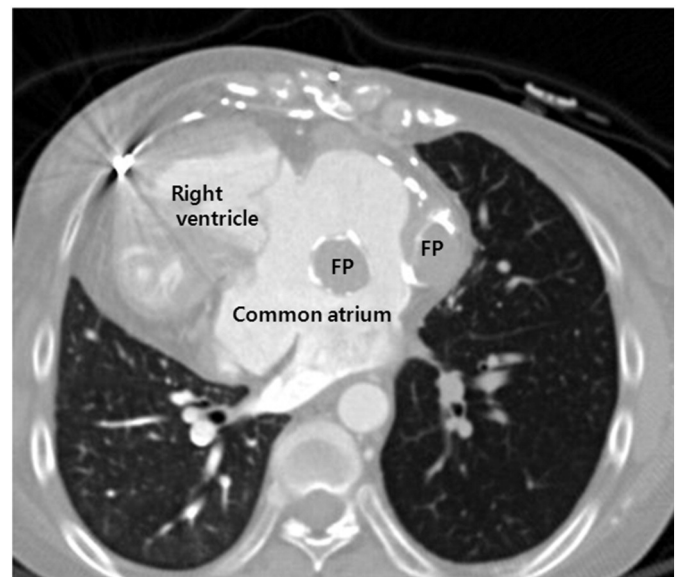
Chest CT scan of a patient with highly recurrent IART. This patient had right ventricle type single ventricle with mitral atresia, left isomerism, dextrocardia and dual Fontan pathway after LT Fontan conversion. In this patient, IART was highly recurrent despite Fontan conversion, right side maze operation and atrial pacing. FP indicates Fontan pathway.
